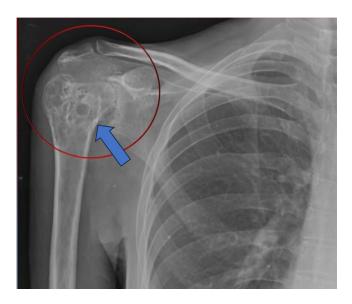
X-ray of right shoulder joint anteroposterior view shows erosive destruction of right humeral head with loss of contour, subchondral cysts, and erosions of visualized part including greater and lesser tuberosity and glenoid margins (blue arrow).
